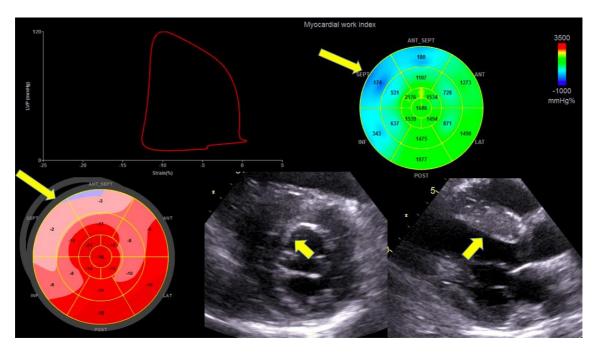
Example of Myocardial Work (MW) estimation in a patient with non-obstructive hypertrophic cardiomyopathy. At the bull's eye in the high right panel evidence of reduced MW at septal and inferior segments (blue segments), corresponding to the same area of low myocardial strain as shown in the bull's eye in the lower left panel, and to the more hypertrophic area as shown at transthoracic echocardiography (yellow small arrows).
